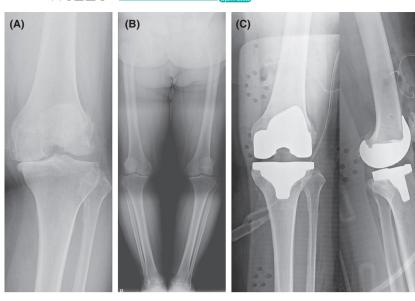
(A) An anteroposterior (AP) radiograph of a 56-year-old female patient who developed Kellgren–Lawrence (K-L) grade IV osteoarthritic changes of the left knee that failed to respond to conservative management. (B) A preoperative standing AP radiograph of the bilateral lower extremities showed a left hip–knee–ankle (HKA) angle of 10.1°. (C) Radiograph following left total knee arthroplasty with a 9 mm polyethylene liner
